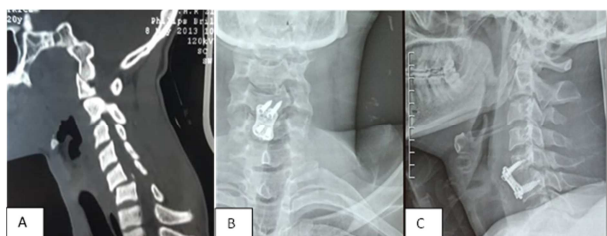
(A, B, C). Pre-operative CT scan (A) and Post-operative control X-ray of the 15-year-old C5-C6 dislocation patient after a brawl. Incidence from the front (B) and profile (C) objectivizing the plate.
